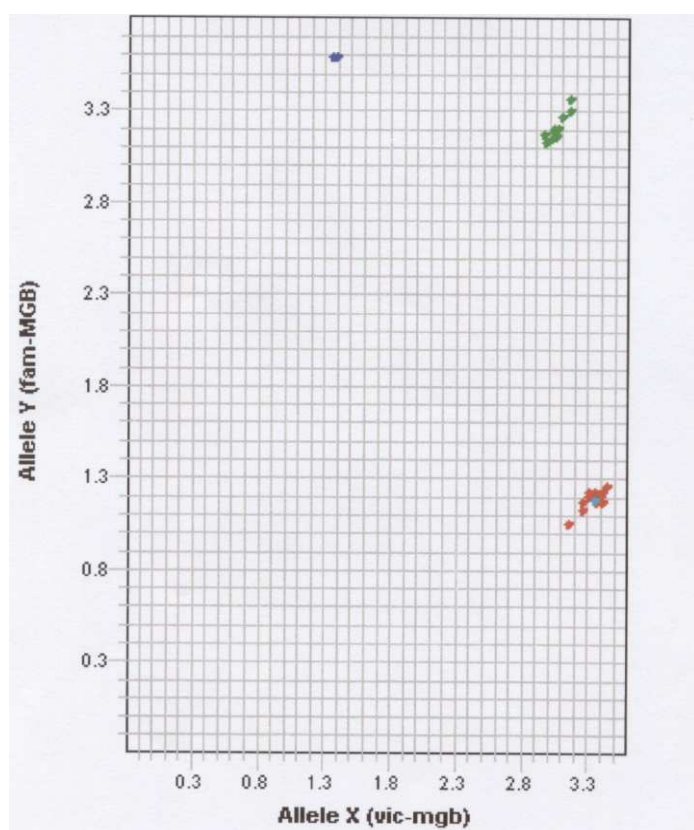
Allelic discrimination plot. TT, blue spot; CT, green spots; CC, red spots.
